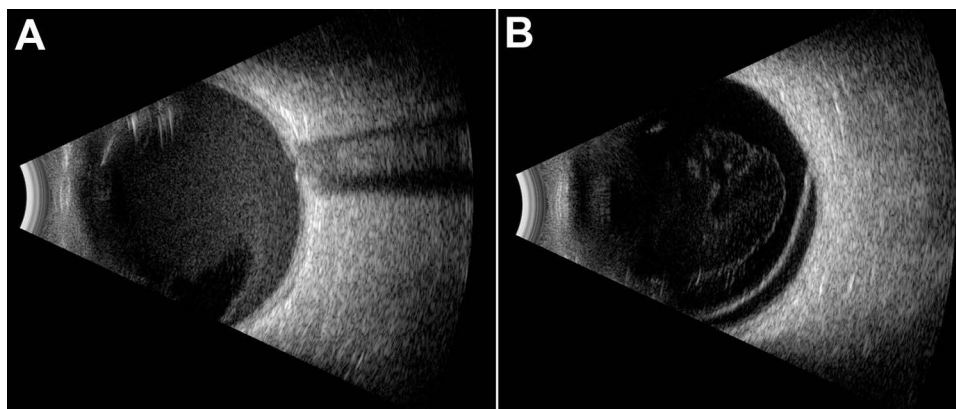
B-scan ultrasonography of vitreous hemorrhage and retinal detachment B-scan ultrasonography demonstrating (A) vitreous hemorrhage and (B) retinal detachment.
